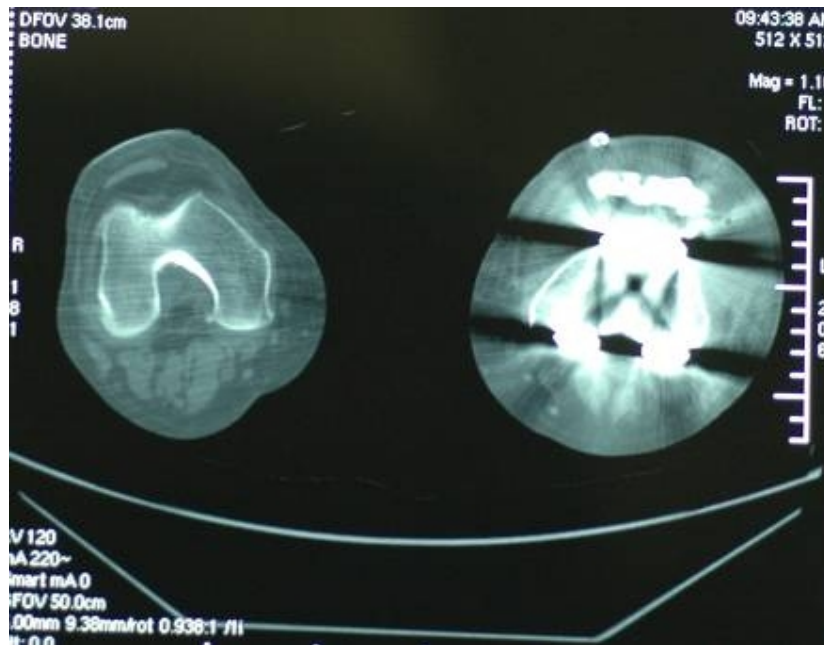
CT-scan of aligned and resurfaced patella
